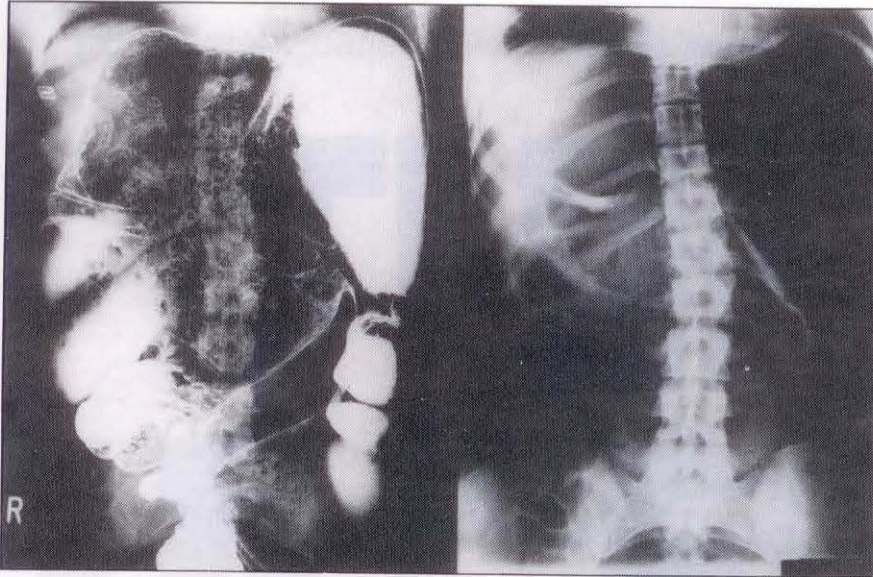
Barium enema and plain abdominal x-ray showing gross colonic distension proximal to the sigmoid colon
